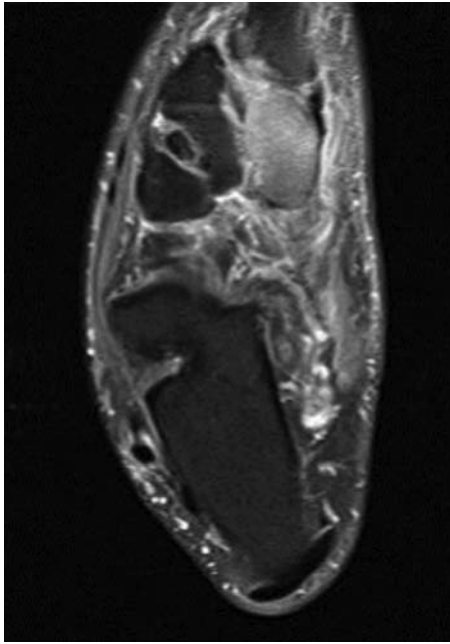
Preoperative axial T2 magnetic resonance image of the right foot revealed the presence of moderate marrow edema within the medial cuneiform emanating from a probable non-displaced sub-cortical fracture along the distal margin. Additional mild marrow edema in the proximal and lateral margin of the first metatarsal base, which may represent an additional stress reaction or contusion, if there has been recent trauma. The nearby Lisfranc ligament is intact.
